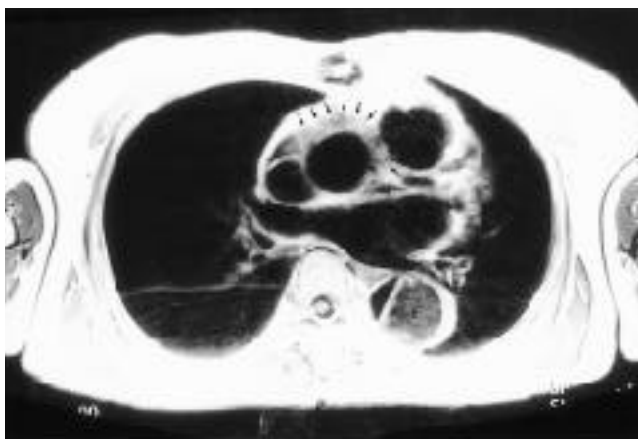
Perigraft thrombosis. Axial spin-echo T1-weighted image shows an ill-defined area of intermediate signal intensity (arrows) surrounding the aortic prosthesis of the ascending aorta. Note descending aorta with remnant false lumen (F).
